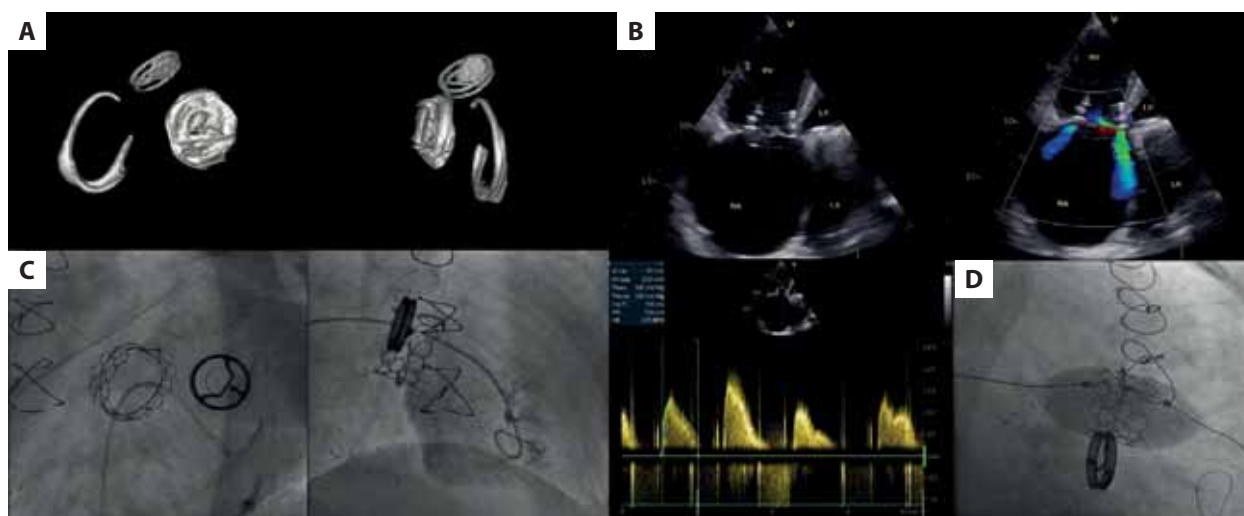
A. Cardiac computed tomography showed the ring shape and downward angle in the septal region. B. Echocardiographic images 2 days after transcatheter tricuspid valve-in-ring (TVIR). C. Angiographic images after transcatheter TVIR Myval implantation. D. Angiographic images of implantation of the 32-mm Myval transcatheter heart valve
